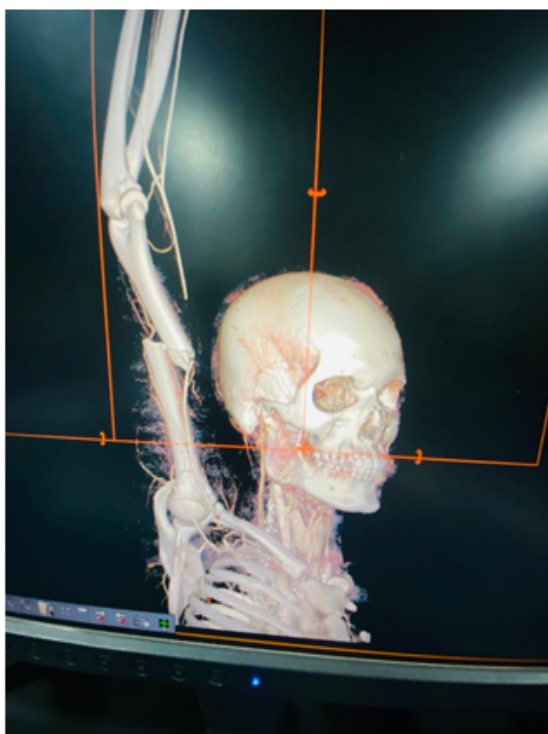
Pre op CT-angio showing Brachial artery filling defect
